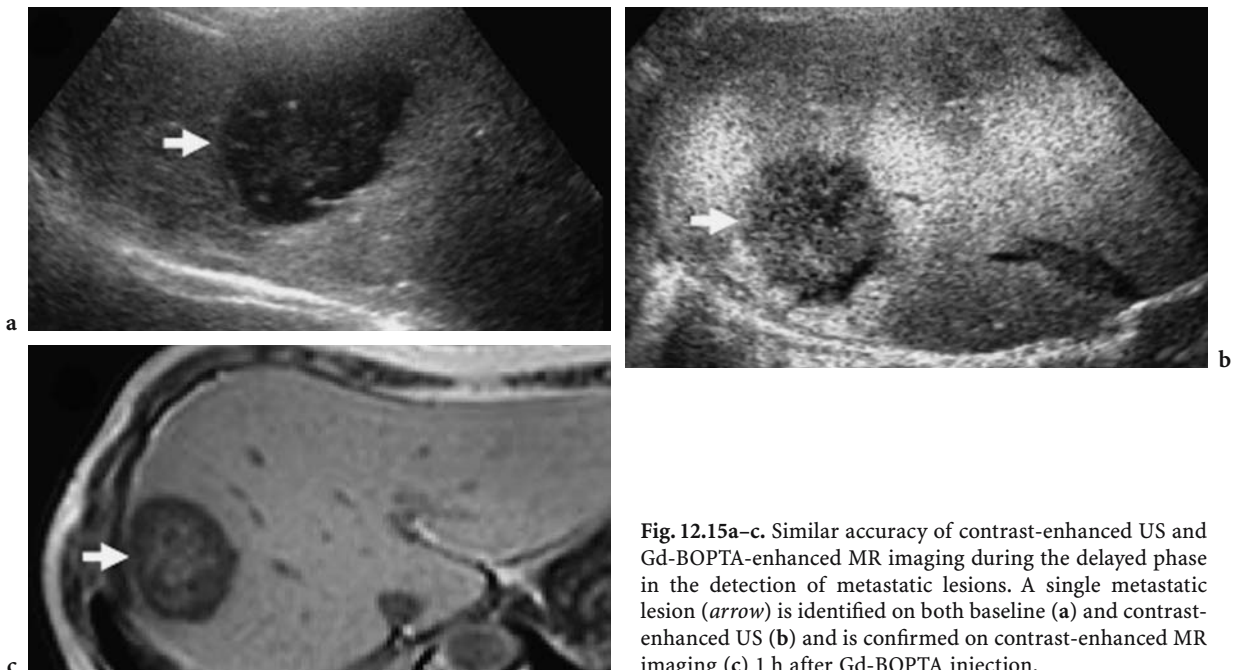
Similar accuracy of contrast-enhanced US and Gd-BOPTA-enhanced MR imaging during the delayed phase in the detection of metastatic lesions. A single metastatic lesion (*arrow*) is identified on both baseline (a) and contrast-enhanced US (b) and is confirmed on contrast-enhanced MR imaging (c) 1 h after Gd-BOPTA injection.
